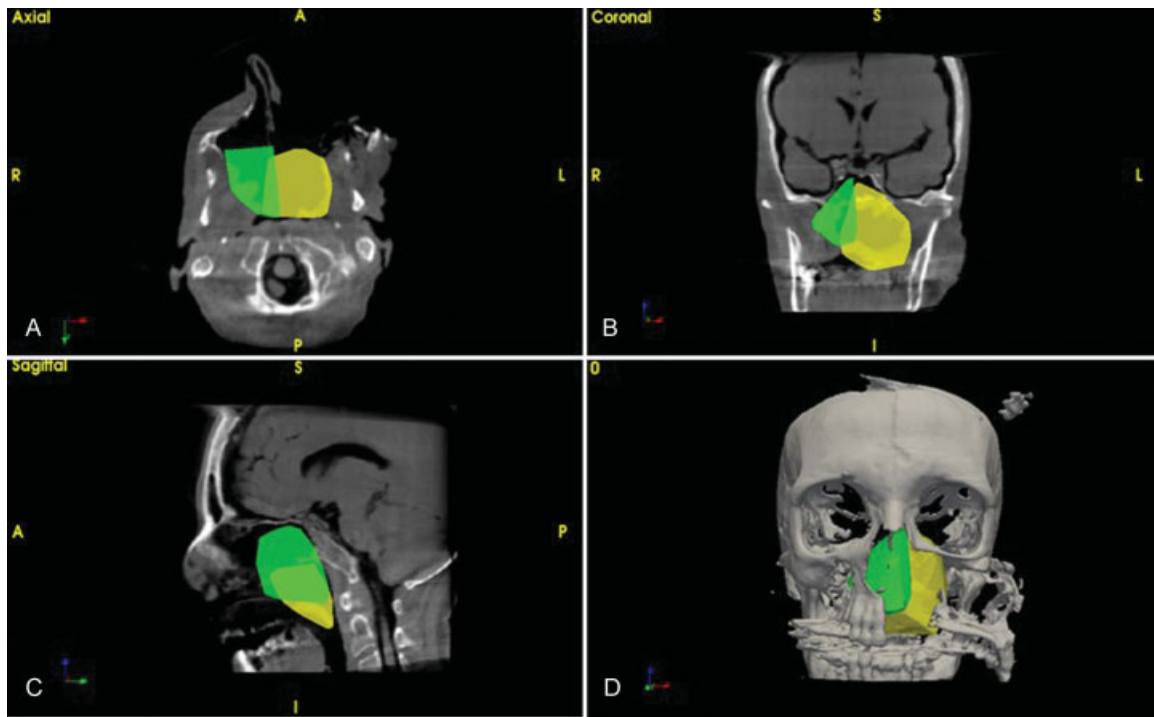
Surgical access volumes for endoscopic endonasal (green) and maxillary swing (yellow) approaches. (A) Two-dimensional visualization of access volumes in cone-beam computed tomography axial, (B) coronal, (C) sagittal slices, and (D) three-dimensional reconstruction and surgical volume. A: anterior, P: posterior, S: superior, I: inferior, R: right, L: left.
